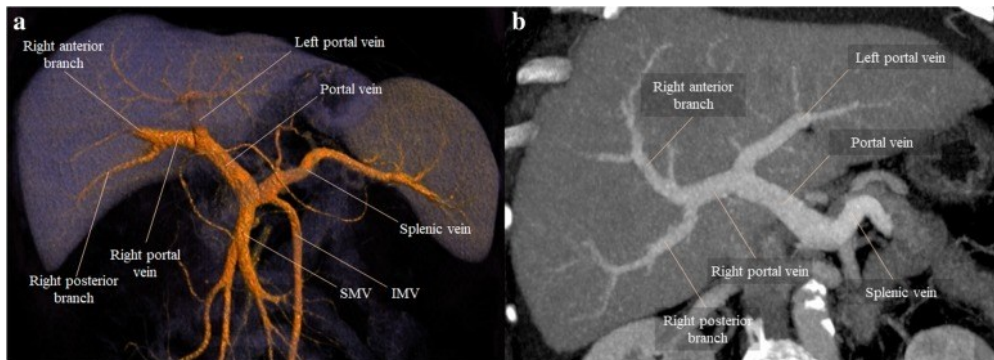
Normal portal vein branching patterns as visualized by contrast-enhanced CT imaging (14)
